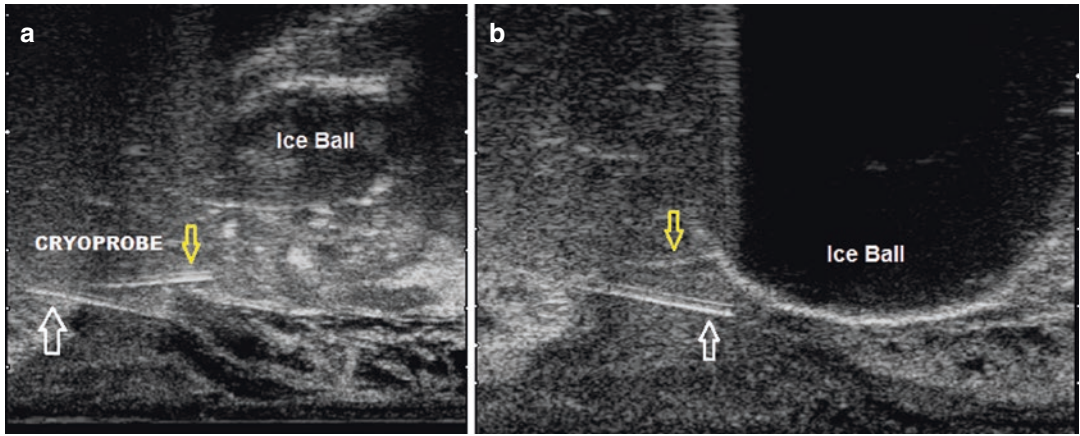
Chiba needle (*white arrow*) to inject antibiotic solution in the space between two layers of Denonvillier’s fascia, during and after complete freezing of the prostate. Ultrasound longitudinal view
